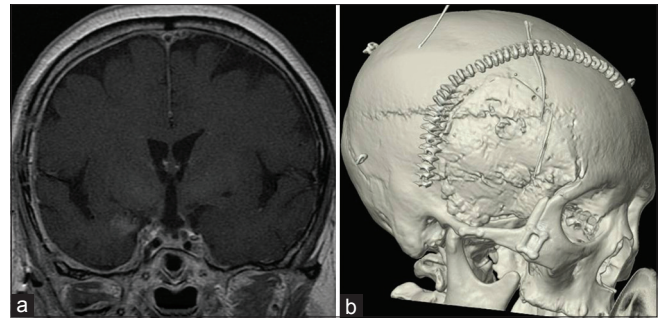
Postoperative MRI and size of craniotomy. (a) Tumor was totally removed. (b) Size of craniotomy
